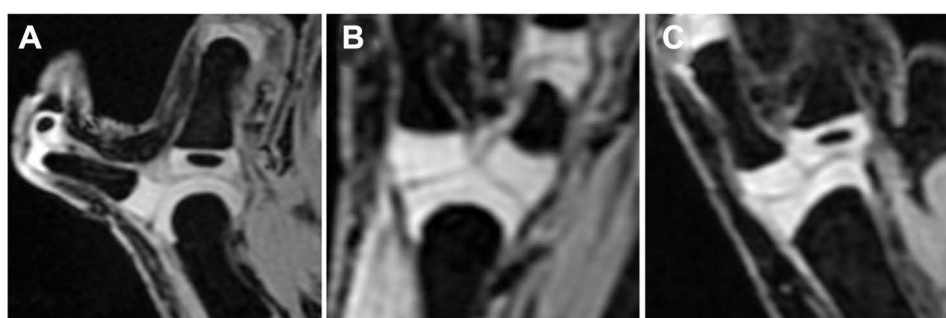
MR images show different cartilaginous joint surface shape of the metacarpal in Type 2. (A) The broad distal metacarpal articular cartilage with smooth surface. (B) The distal metacarpal head had two articular surfaces separated by elevated cartilaginous ridge. (C) The surface of the distal metacarpal articular demonstrate concave in one side and convex in the other side.
